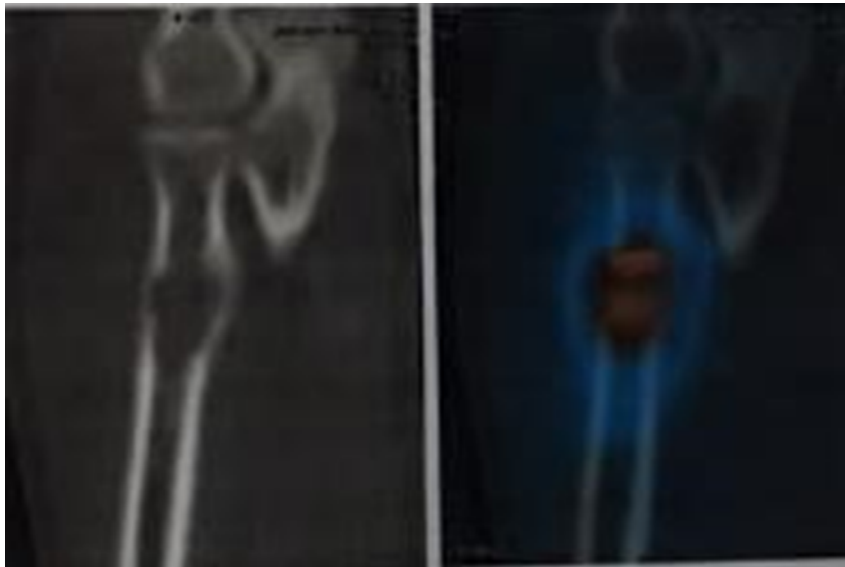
Plain radiograph revealing lytic lesion present over proximal one third of radius
